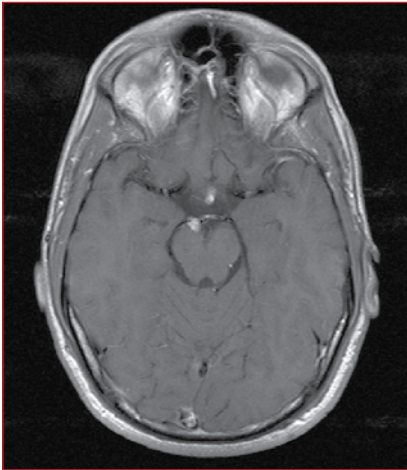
MRI of brain demonstrating a small midbrain haemangioblastoma (arrows)
